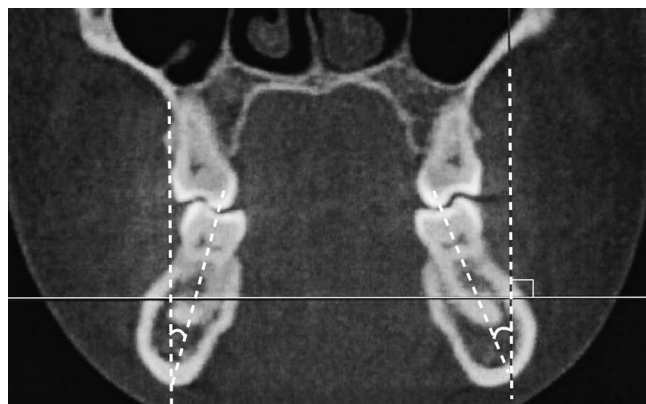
CBCT showing coronal section of mandibular first molars.
